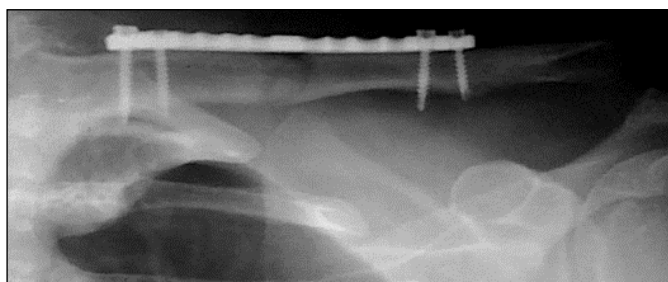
Radiography in postoperative anteroposterior incidence showing fracture reduction and fixation by plate and screws.
